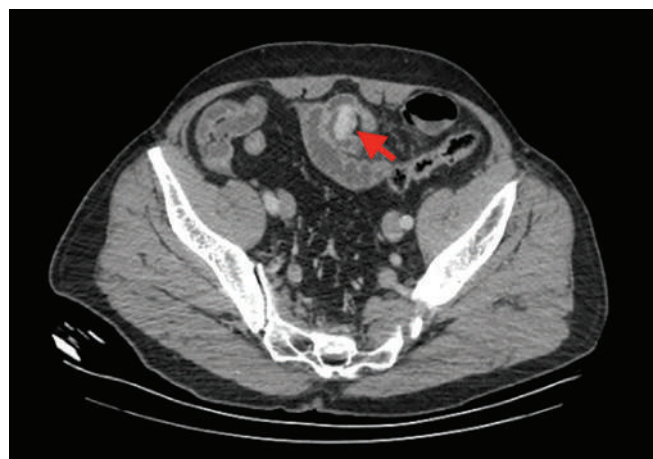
Contrast-enhanced abdominal CT obtained one year prior to presentation (axial view): retrospective evaluation reveals focal jejunal wall thickening causing partial luminal narrowing.
